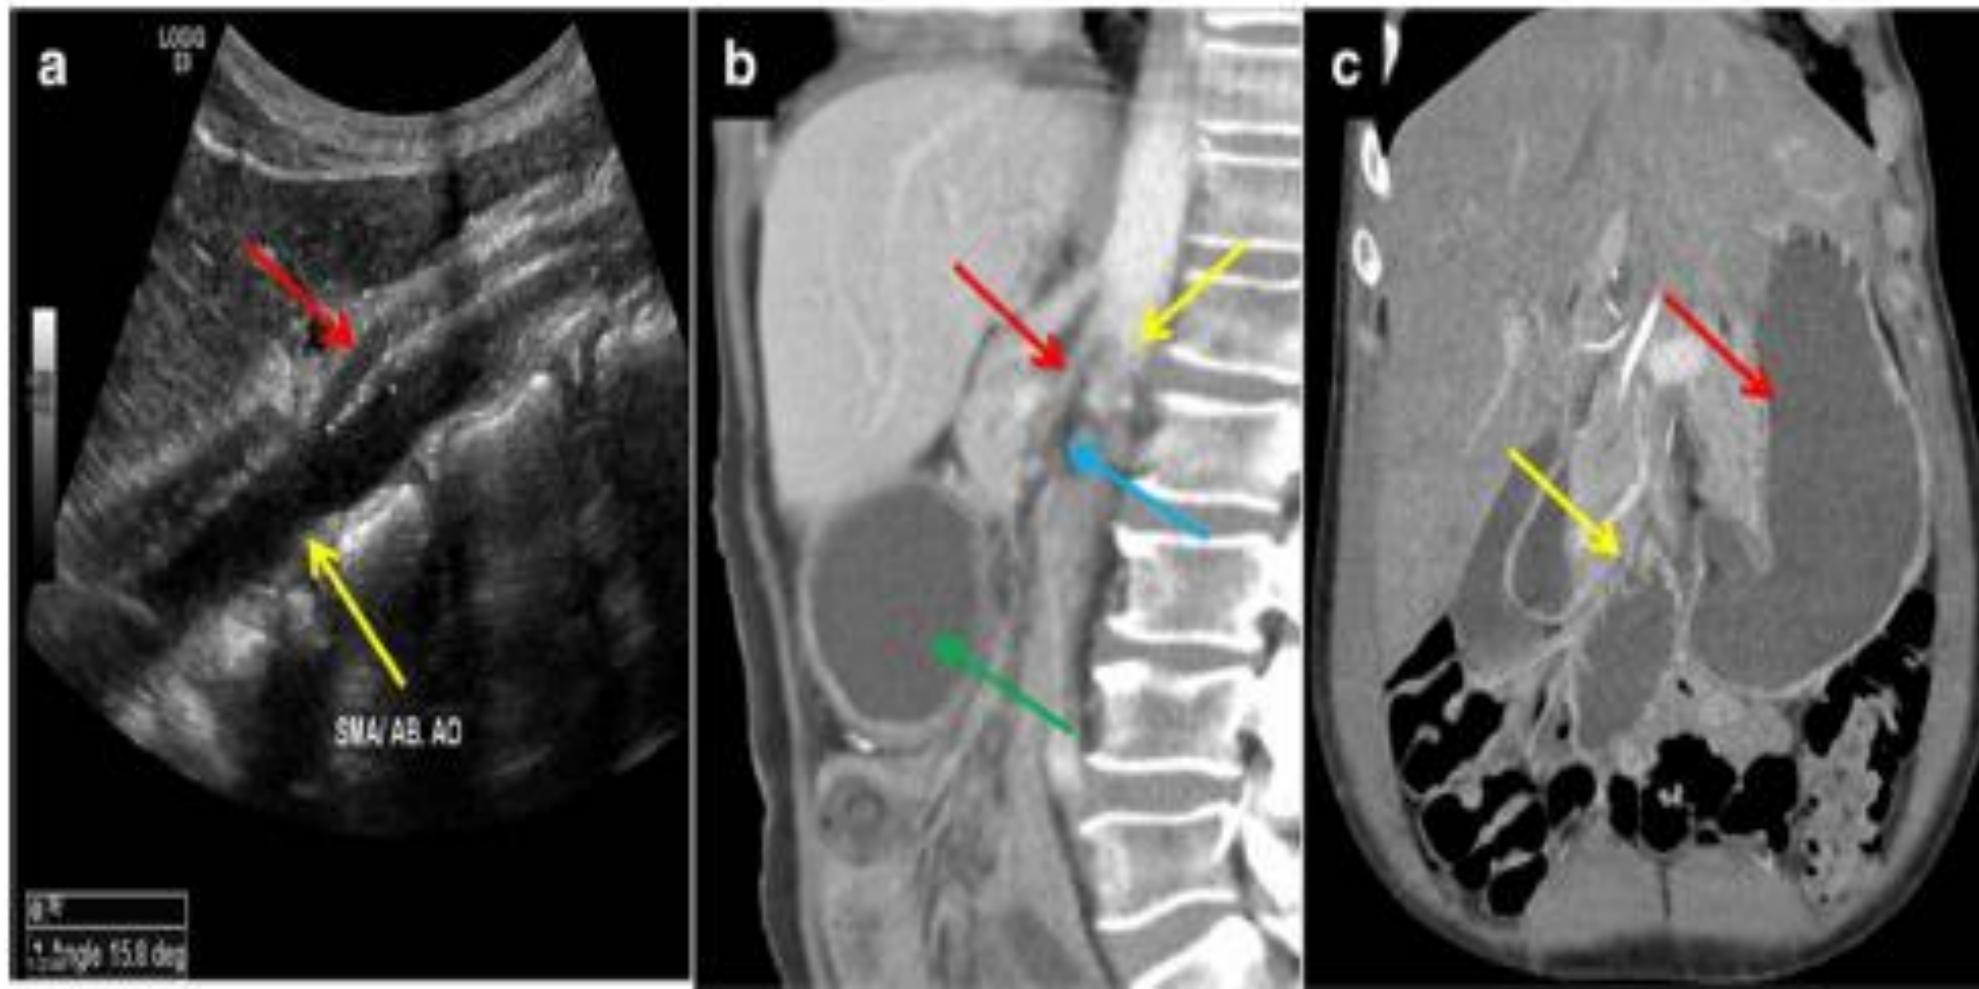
Superior mesenteric syndrome in different patients. a Grayscale ultrasound in mid-sagittal plane shows aortomesenteric angle of 15.8 degrees (measured with calipers, SMA - red arrow, and aorta - yellow arrow). b Sagittal CT image showing compression of the 3rd part of the duodenum (blue arrow) between the SMA (red arrow) and aorta (yellow
